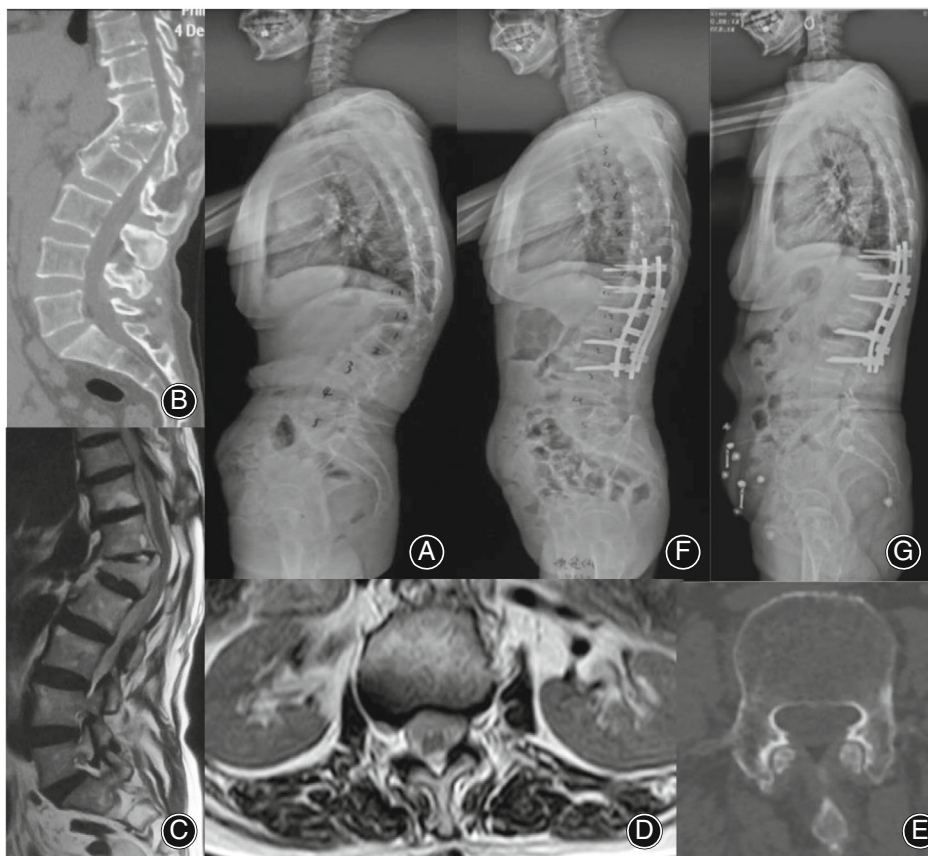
Posttraumatic kyphosis secondary to old fracture at L1 in a 63-year-old female patient (a). She was noticed with highly wedging deformation of fractured vertebral body (b, c), normal paraspinal muscles (d) and normal bone quality (e; CT attenuation: 168.0 HU). Then she received instrumented fusion from T10 to L3 and Grade IV osteotomy at L1(f). The kyphosis correction maintained well till 4 years follow-up (g).
